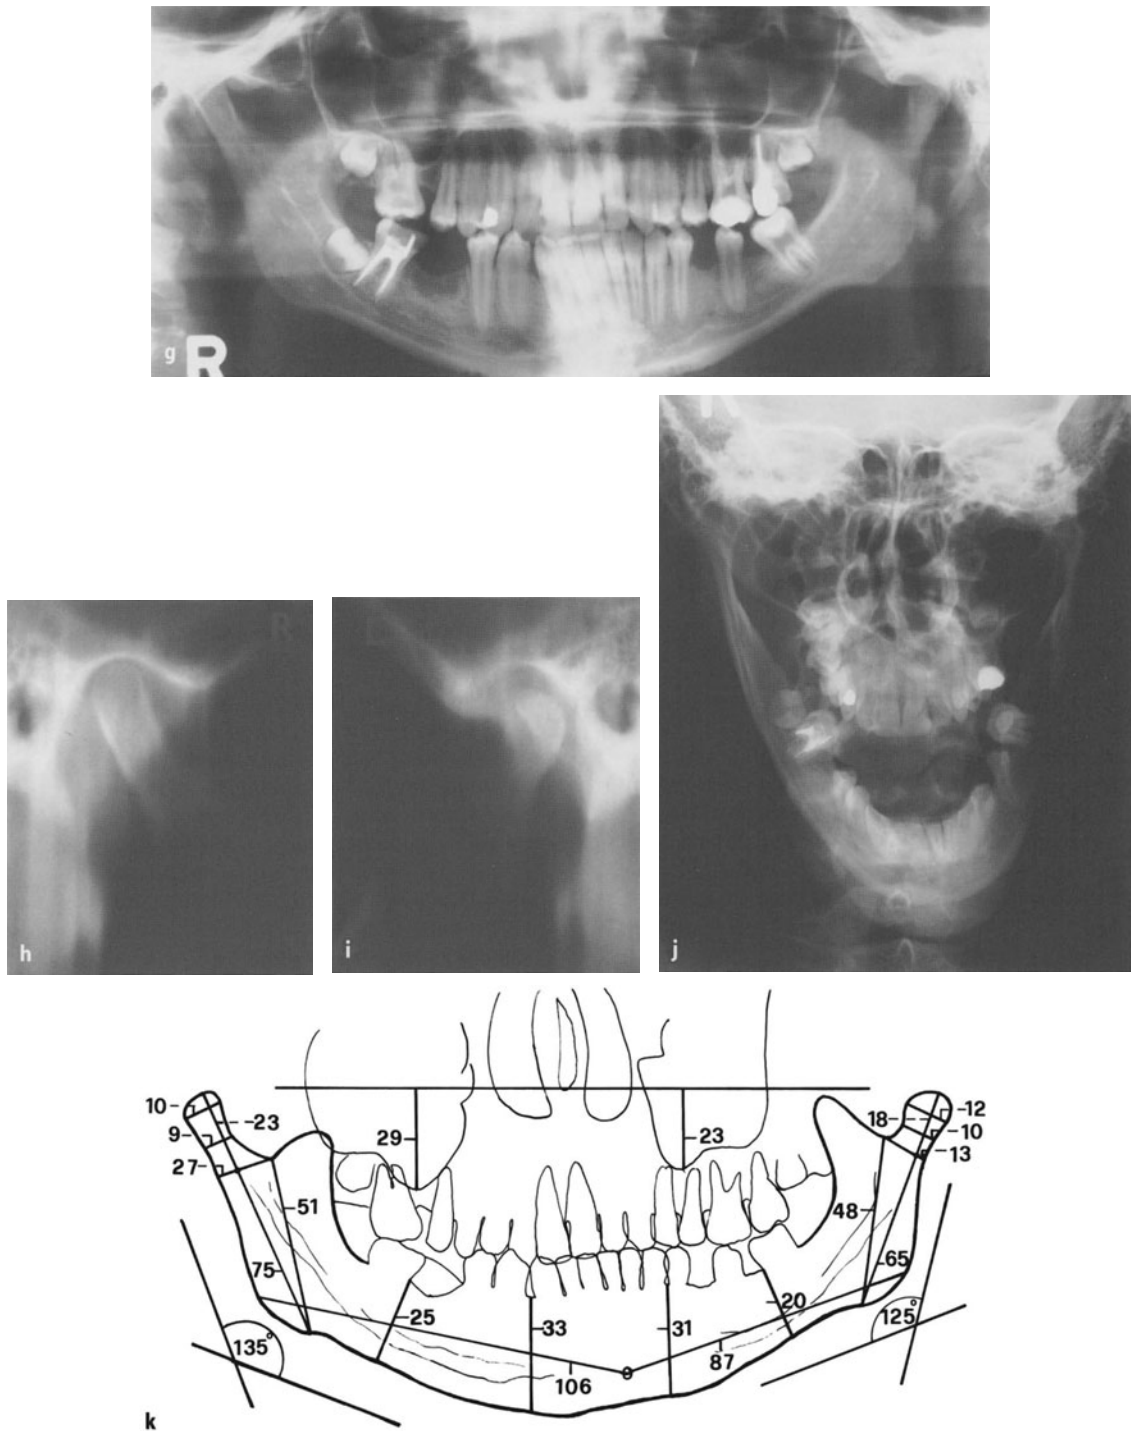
Unilateral H.E., slender type, of 10-year duration. g, h The TMJ tomograms show clearly the difference in the shape of the two sides. If they had included the ascending rami and angles also, the difference would have been visualized much better. i, j The p.a. projection of the mandible in the open mouth position discloses the enormous elongation of the right mandible even better than the panoramic view, while the lateral cephalogram does not show any asymmetry or antemandibulism-like position of the mandible. k The tracing of the panoramic radiograph shows the actual differences between the various sections of the two hemimandibles
